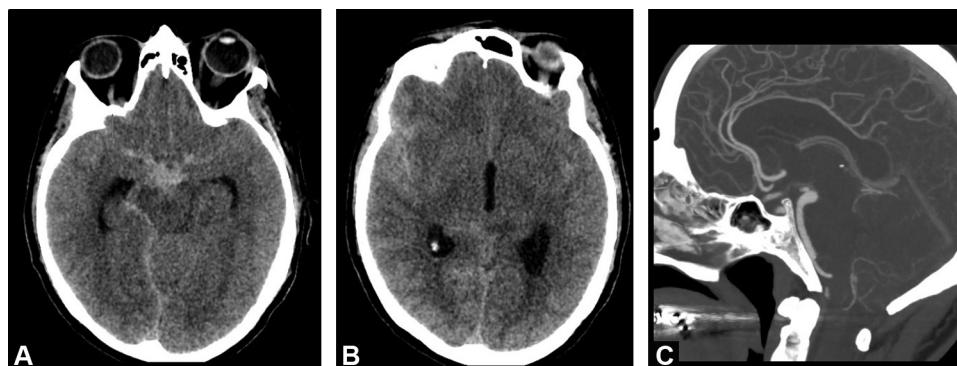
Initial unenhanced cerebral CT (A, B). Cerebral CT angiogram of the circle of Willis with sagittal MIP reconstruction (C).
